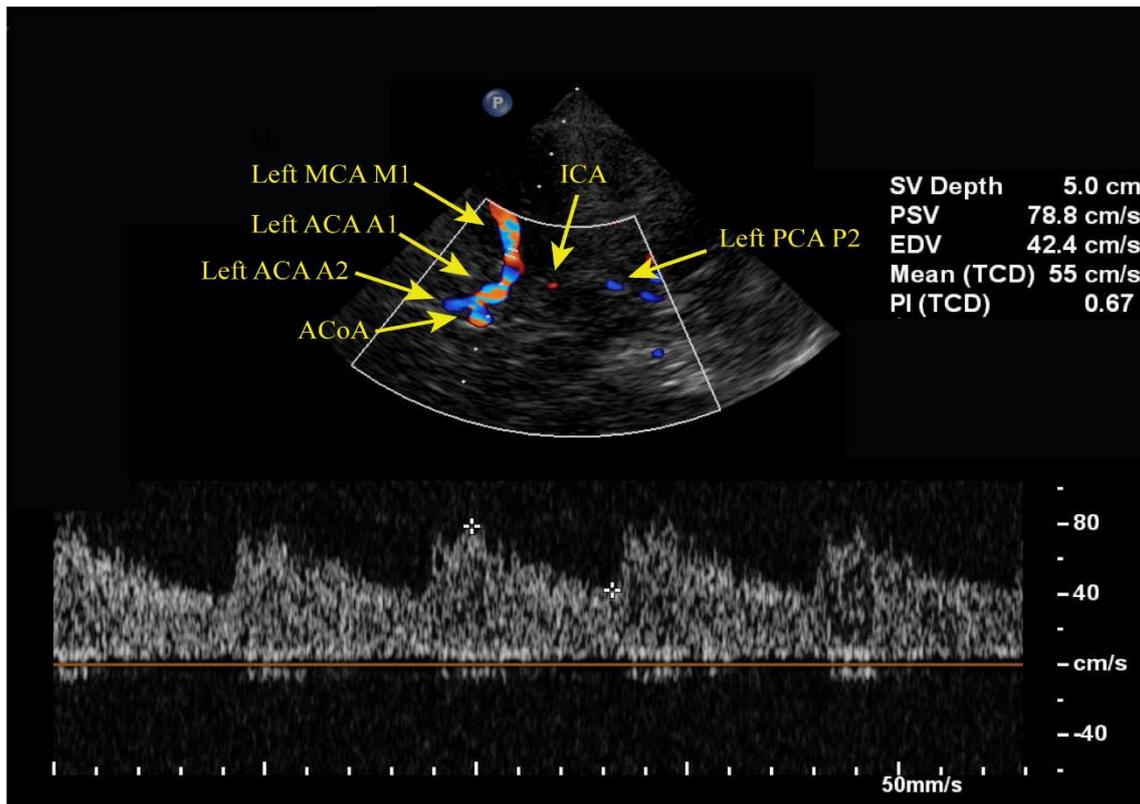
TCCS showing normal flow velocities in the left MCA. ACA: anterior cerebral artery, ACoA: anterior communicating artery, EDV: end-diastolic velocity, ICA: internal carotid artery, MCA: middle cerebral artery, mean (TCD): mean flow velocity, PCA: posterior cerebral artery, PI (TCD): pulsatility index, PSV: peak systolic velocity, SV depth: sample volume depth, TCCS: transcranial color-coded duplex sonography.
